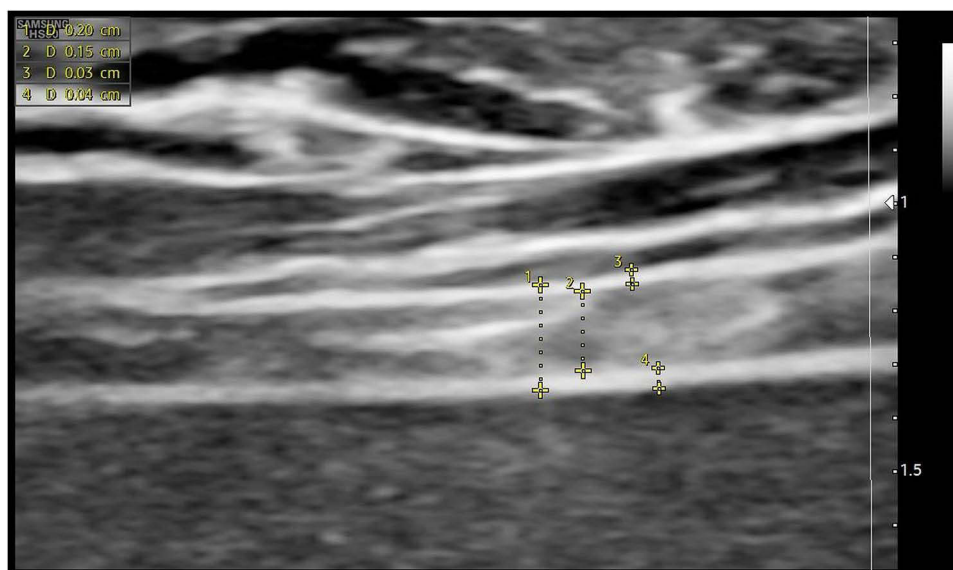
B-mode ultrasound assessment of hemidiaphragmatic thickness. Acquired at the 8th–9th right intercostal space in the zone of apposition (ZOA) with a 10 MHz linear probe. The diaphragm appears as a hypochoic central layer (2), between two echogenic layers: diaphragmatic pleurae (3) and peritoneum (4). Thickness was measured at end-inspiration (TEI, 1) and end-expiration (TEE, not shown). $TF = [(TEI - TEE) / TEE]$. 1. TEI. 2. Diaphragm Layer. 3. Pleura Layer. 4. Peritoneum Layer. Abbreviations: B-mode, Brightness Mode; ZOA, zone of apposition; TEI, thickness at end-inspiration; TEE, thickness at end-expiration; TF, thickening fraction.
